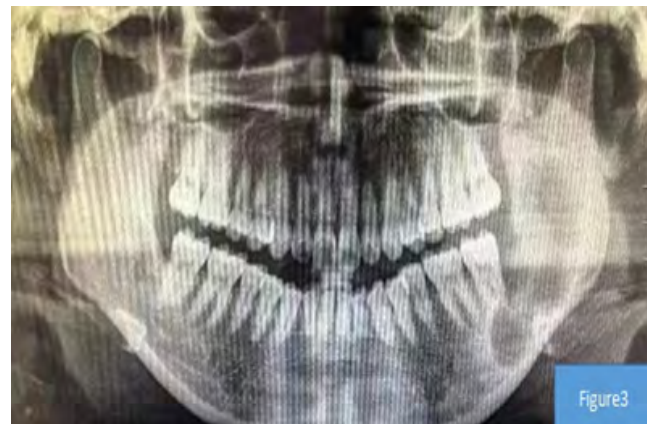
The expression is a picture of the patient's postoperative oral X-ray examination results.
